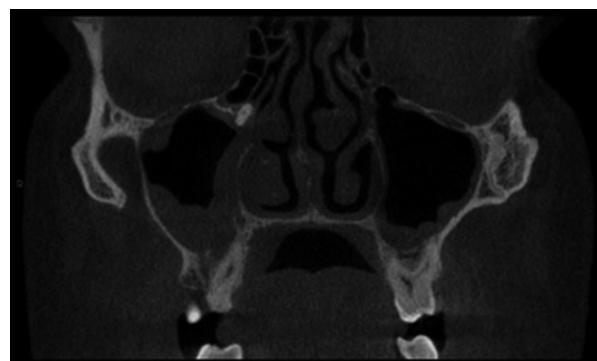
CBCT of the maxillary sinuses (coronal view) showing migration of the mesiobuccal root of the right first upper molar to the medial antral wall, close to the ostium.
